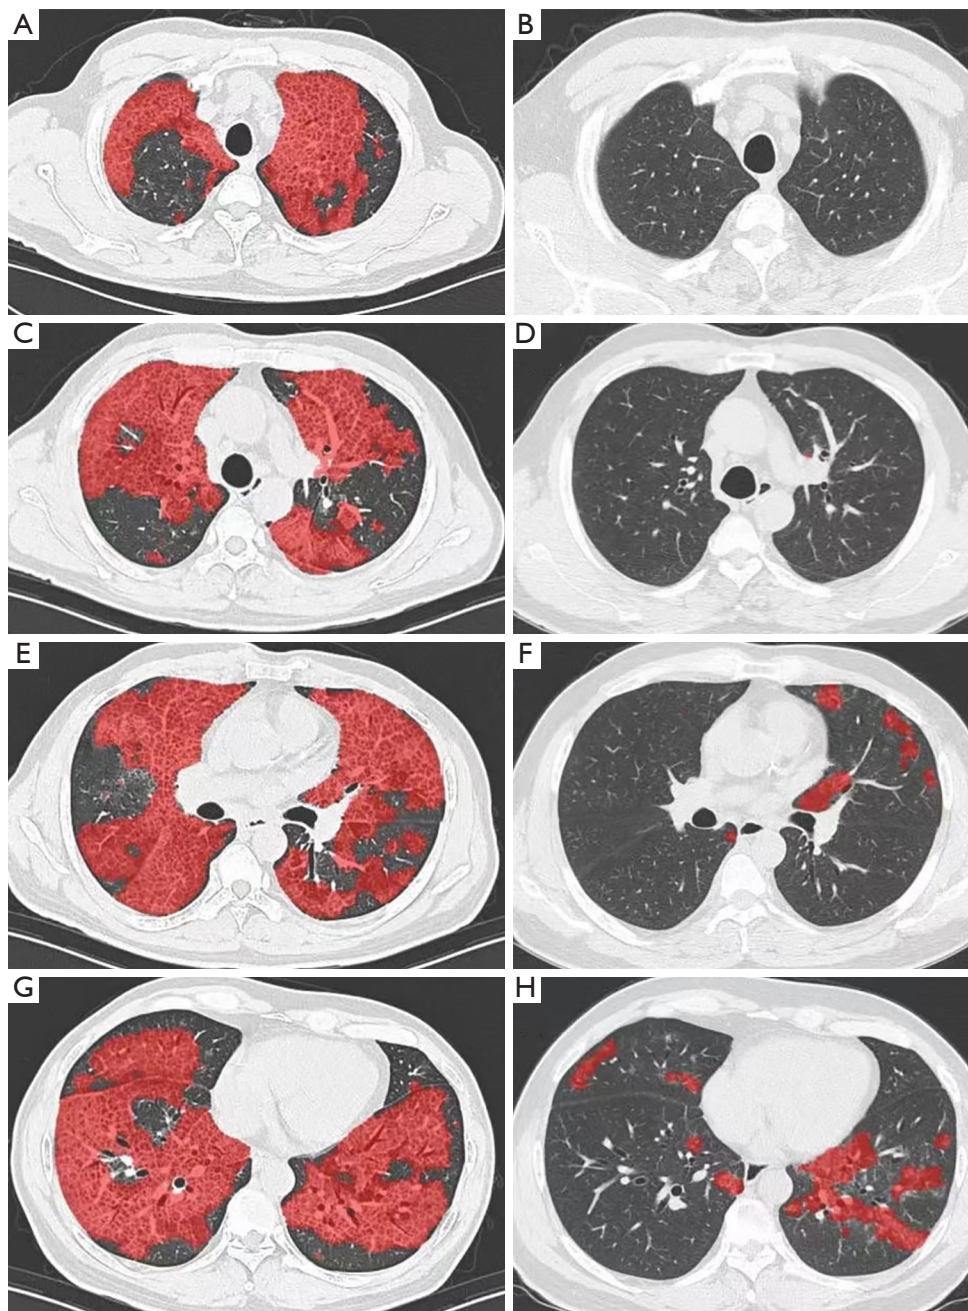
Chest HRCT images at the baseline and after 12 months of follow-up in a 57-year-old male patient with severe PAP. (A,C,E,G) Baseline HRCT [total opacification of whole lung (%) =63.2%]. (B,D,F,H) HRCT images at the 12-month follow-up [total opacification of whole lung (%) =3.6%]. Red color areas: the regions that were considered as lung opacification. HRCT, high-resolution computed tomography; PAP, pulmonary alveolar proteinosis.
